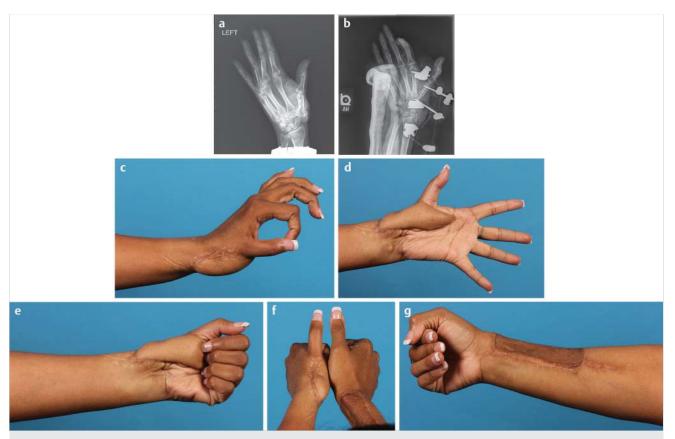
(a) Radiograph demonstrating level of traumatic injury to the left hand. (b) The patient underwent debridement, placement of an external fixator, iliac crest bone grafting with internal pin stabilization, and free radial forearm soft-tissue coverage. (c-g) Postoperative aesthetic and functional outcomes are very good.
